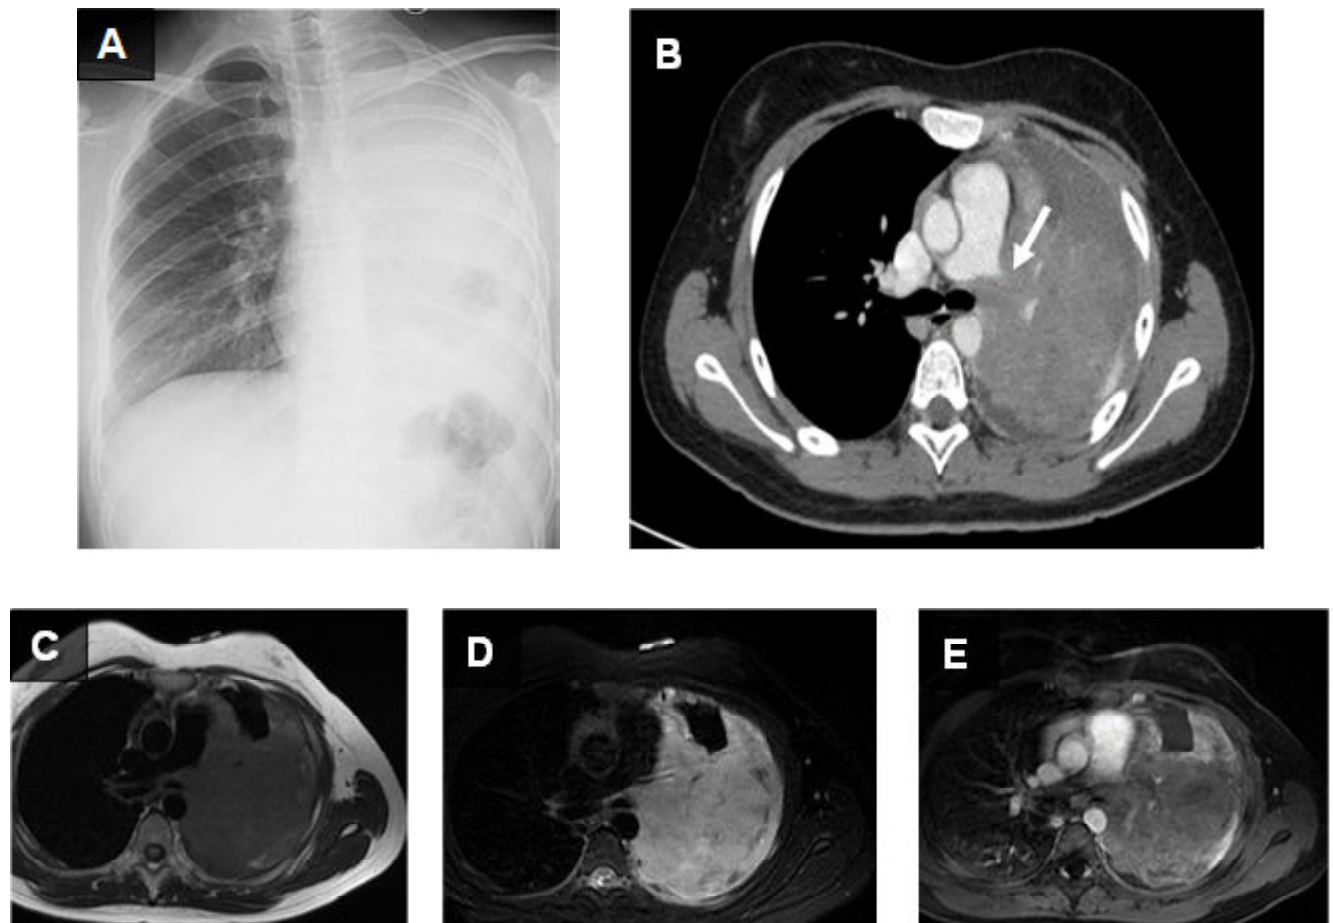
A 14-year-old girl presented with chronic cough and weight loss. (A) The chest radiograph showed a near-total opacity of the left hemithorax without mediastinal shift. (B) Chest CT demonstrated the heterogeneous enhancement of the soft tissue mass that occupies the entire LUL and obliterates the left pulmonary artery (Arrow). MRI of the chest revealed a large intrapulmonary mass in LUL, showing intermediate signal intensity on the T1-weighted image (C) and hypersignal intensity on the T2-weighted image (D). After administration of the gadolinium-based contrast agent, there is a heterogeneous enhancement of the mass (E). Note a small left pleural effusion.
